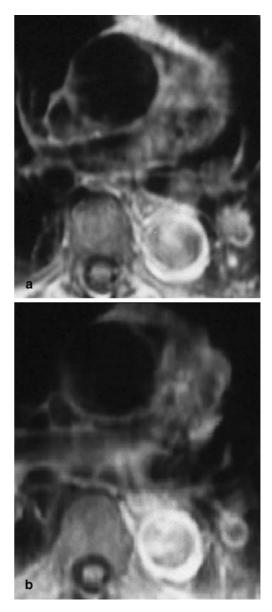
MRI and of the same patient (patient 7). Contrast-enhanced transverse T1-weighted SE-image shows wall thickening and significant enhancement of the thoracic aorta (a) with no improvement during follow-up (b)
